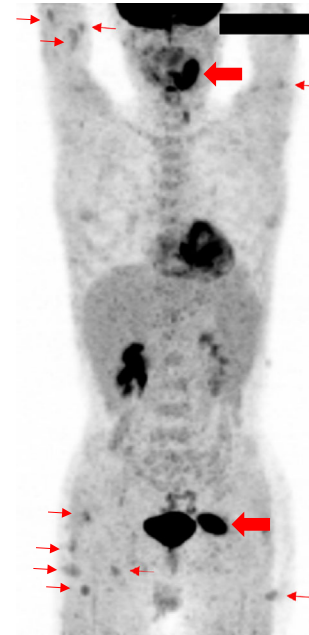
^{18}F -fluorodeoxyglucose positron emission tomography (FDG-PET) shows FDG accumulation in the gingival mass, the systemic eruptions, and the gluteal muscle. Multiple pulmonary nodules show poor FDG avidity on FDG-PET image.
